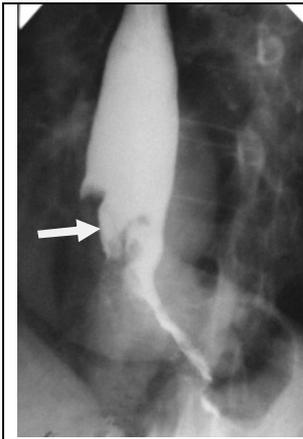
Radiograph of an esophagus in left oblique projection. Boundary filling defect is detected beginning from the bottom third of thoracic department of esophagus with rough contours (arrow), passing in circular narrowing in abdominal department. Suprastenotic dilation of esophagus. Cancer of oesophagus.
